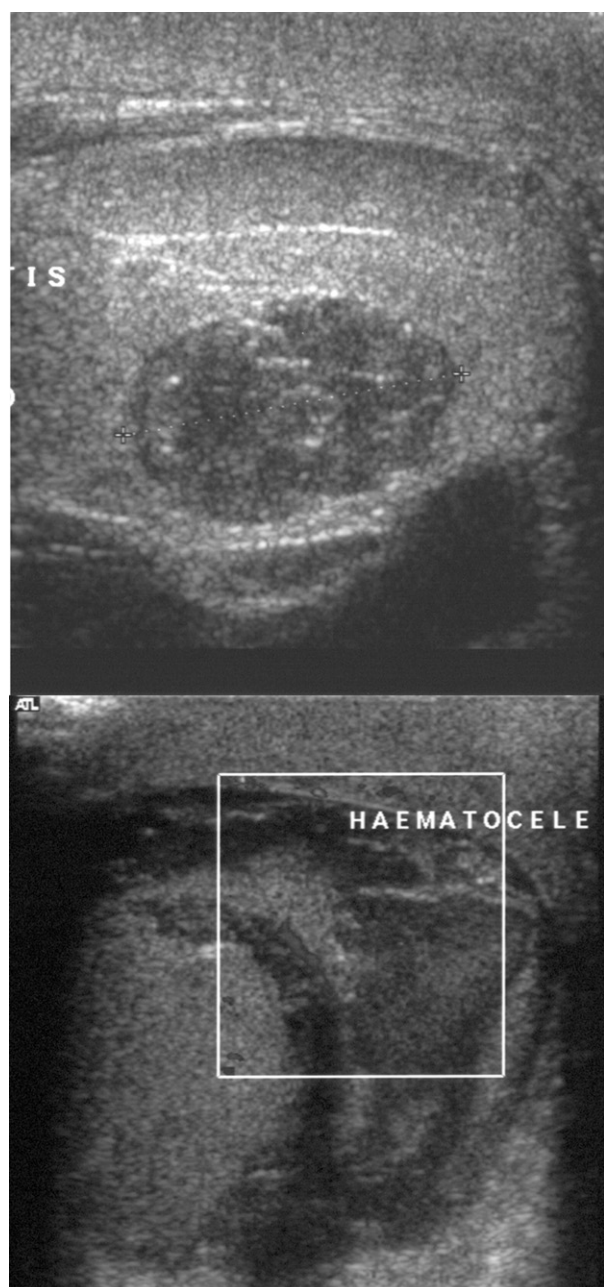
Ultrasound scans showing (Top) intratesticular hematoma and (Bottom) hematocele in 2 different patients.
